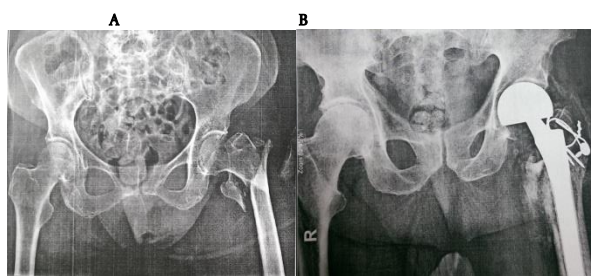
A) Unstable Intertrochanteric Fracture in a 78-year-old Woman; B) Radiography of Hip Joints 3 Months after Long-Stem Cementless Bipolar Hemiarthroplasty
